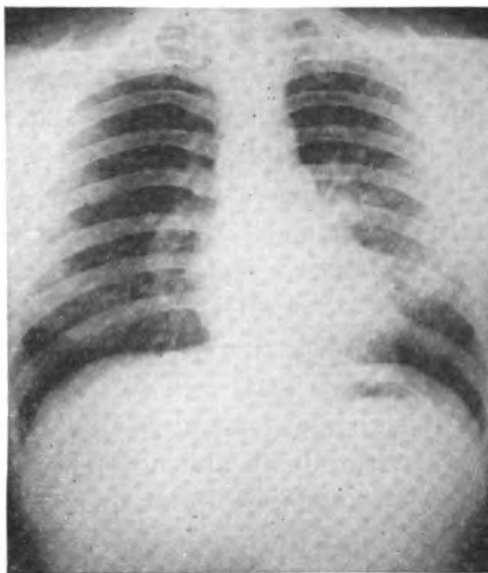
X-ray of chest in September 1944. Infiltrative shadow in left lung extending from hilus towards the periphery between the second and fifth interspaces. The apparently calcific hilar shadow noted in figure 1 (at upper border of fourth costochondral junction) is no longer seen, but appears to have given way to a softer, more diffuse shadow suggestive of "break-down" of the primary lesion.
